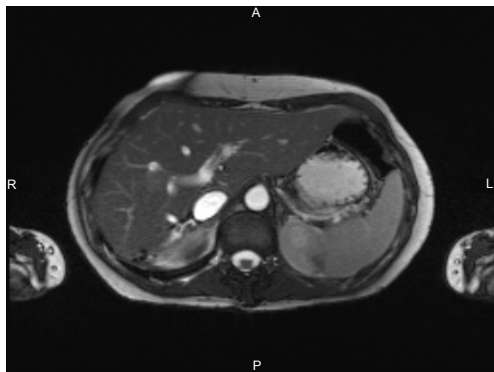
Postoperative MRI T2, IVC of normal caliber at the site of tumour resection.
